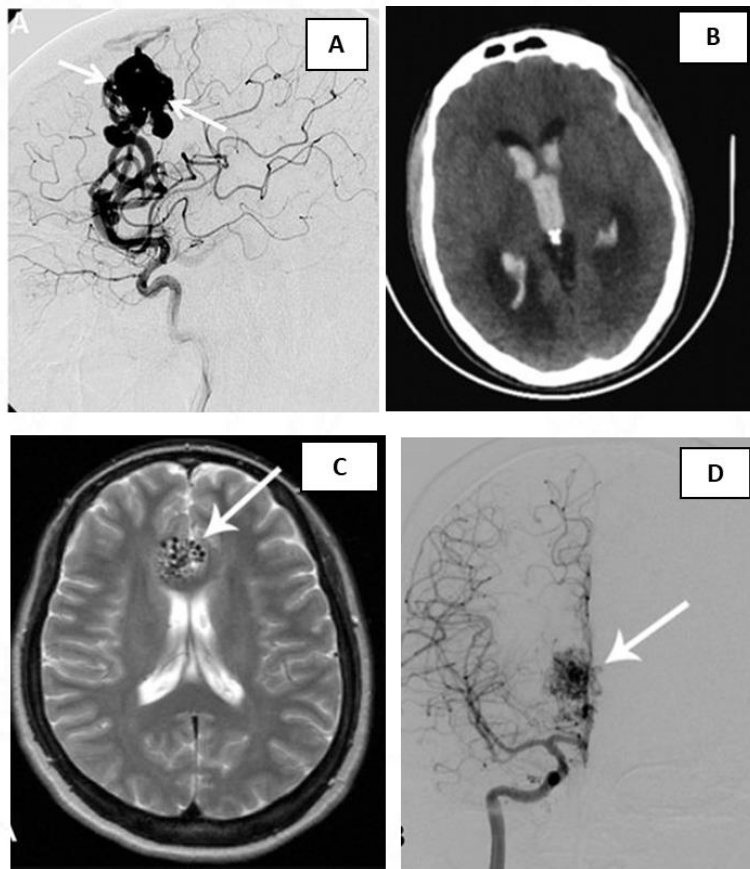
(A). Angiography image of arteriovenous malformation (Sackey et al., 2017); (B) AVM rupture (intraventricular haemorrhage) in CT (Barreau et al., 2014); (C) Magnetic resonance image of AVM; (D) Magnetic resonance angiogram of AVM (Karakida et al., 2013).
